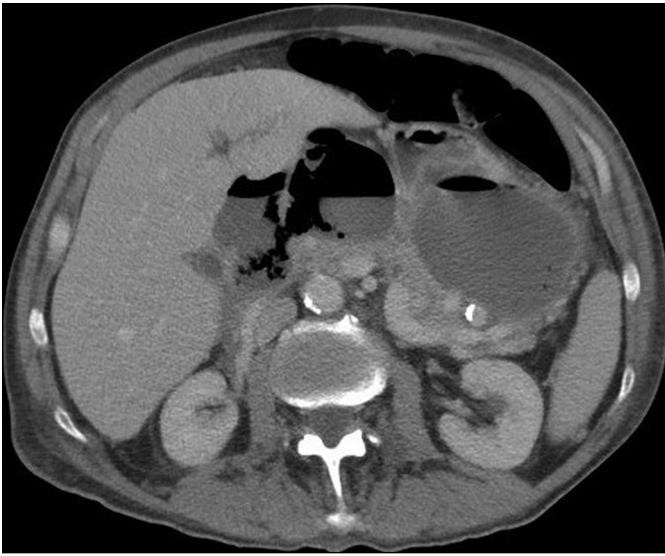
Computed tomography showing a gas-containing collection within the lesser sac.
